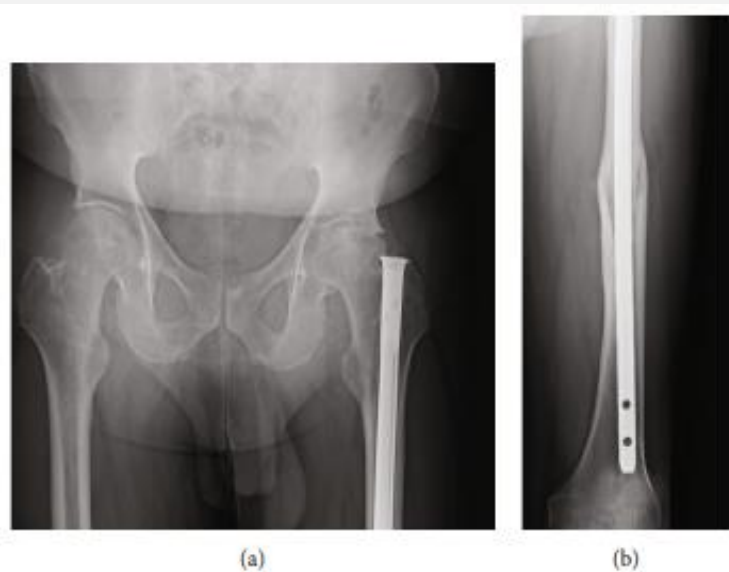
Anteroposterior radiograph showing a universal femoral nail and left hip osteoarthritis (a, b)
